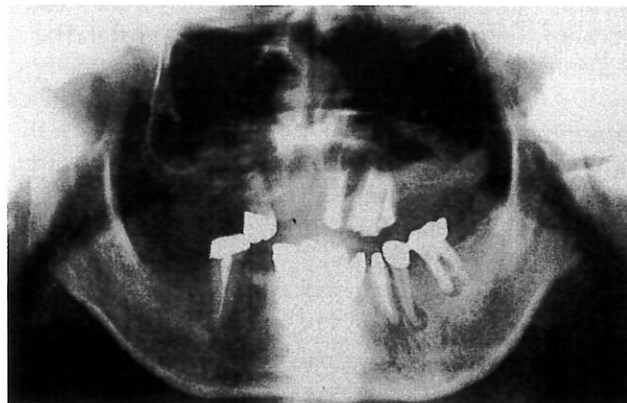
Preoperative orthopantomograph. Marked resorption of the alveolar bone is confirmed.
